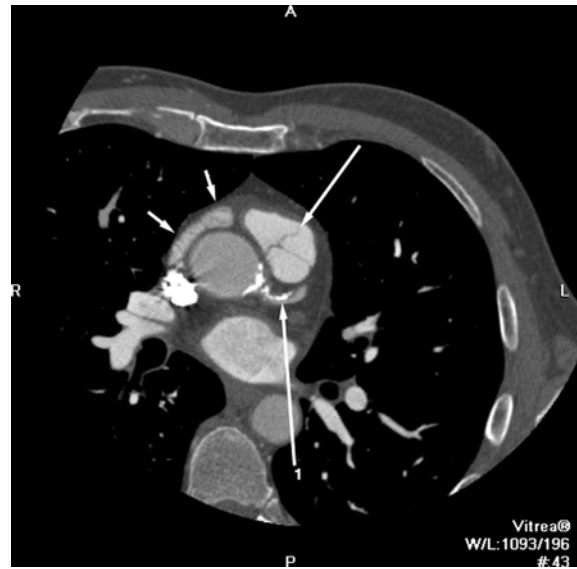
Aortic Sclerosis. Axial images from a contrast-enhanced multidetector CT examination from a 67 year old man with no aortic valve gradient. (a) Image through the right atrial appendage (short arrows) and pulmonary valve (long arrow). Notice the heavy calcification of the aortic root and left main coronary artery (arrow 1).
